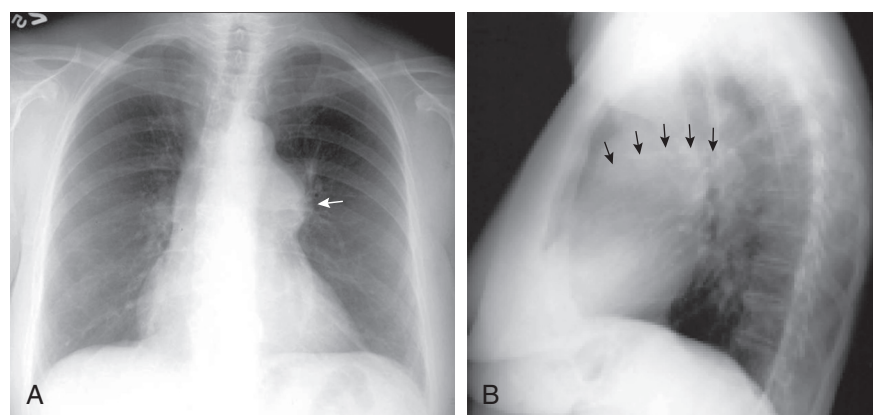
FIGURE e15-9 Chest radiographs of a 56-year-old asymptomatic woman with incidentally discovered pulmonic stenosis. A, PA view showing marked enlargement of the main pulmonary trunk extending into the left main pulmonary artery (*arrow*). B, Lateral view confirming prominence of the pulmonary outflow tract and main and left pulmonary arteries (*arrows*).
